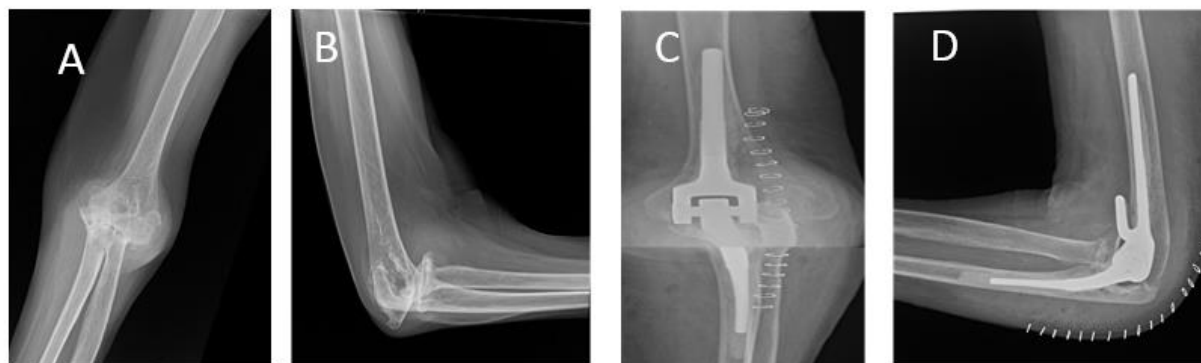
75-year-old female with a long history of elbow pain in a setting of rheumatoid arthritis, not responding to conservative measures. The patient underwent uncomplicated total elbow arthroplasty (TEA): (A-B) preoperative radiographs; (C-D) postoperative views
